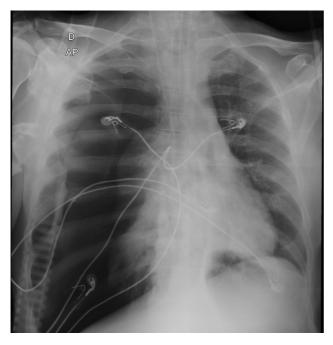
Chest X-ray without visible changes suggestive of aspergillus pneumonia.
